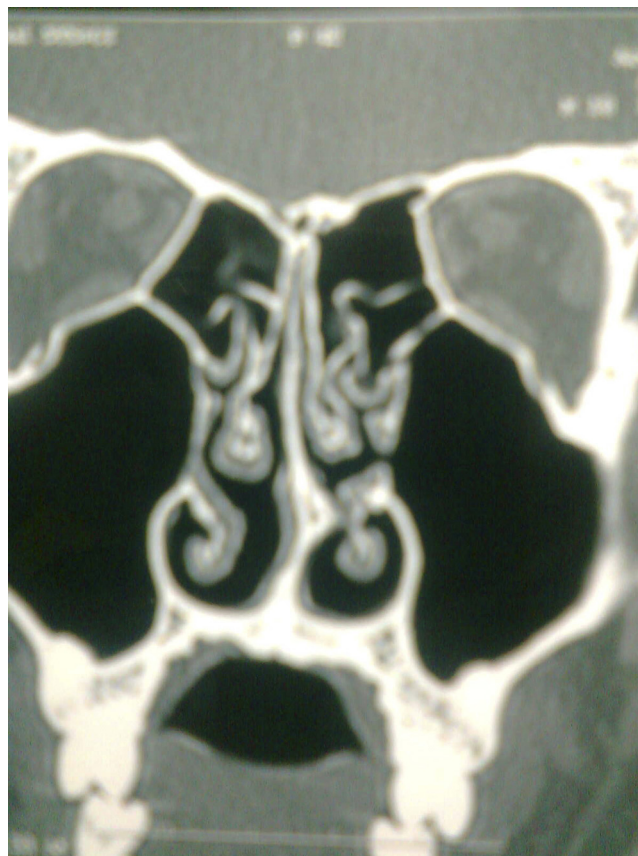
CT scan of the paranasal sinus showing a sharp spur in left nostril touching to the left inferior turbinate
